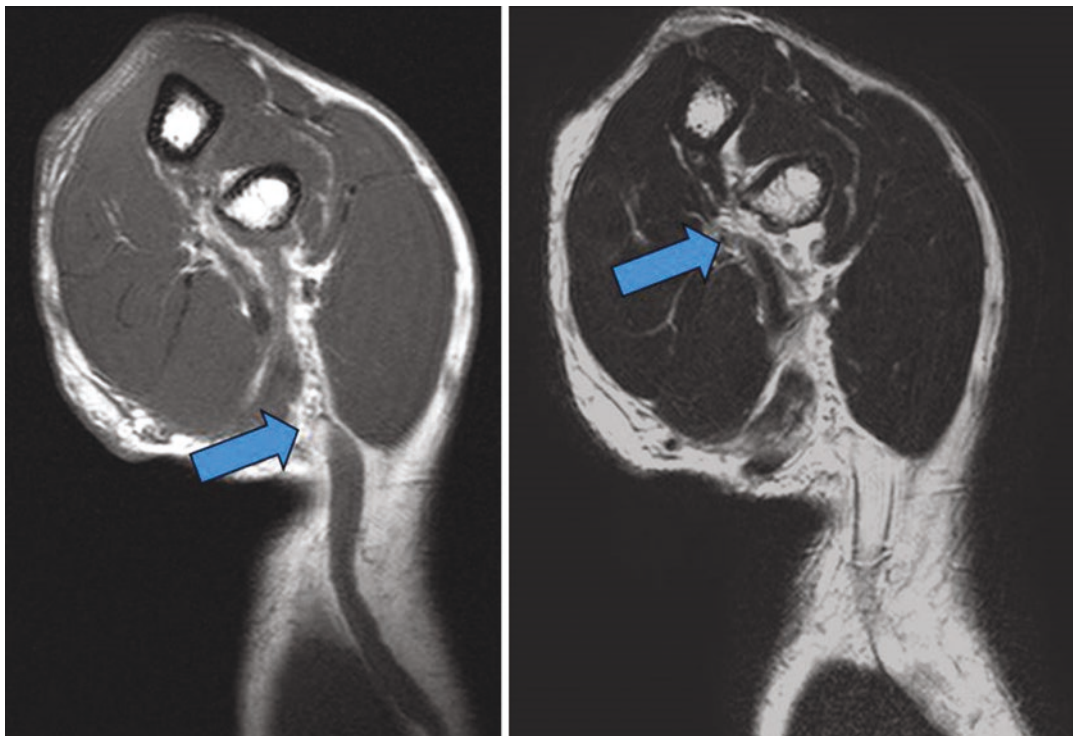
MRI using FABS view (flexion of the elbow, abduction of the shoulder, supination of the forearm) provides full-length images of the biceps tendon from the muscle-tendon junction to its radial tuberosity insertion
